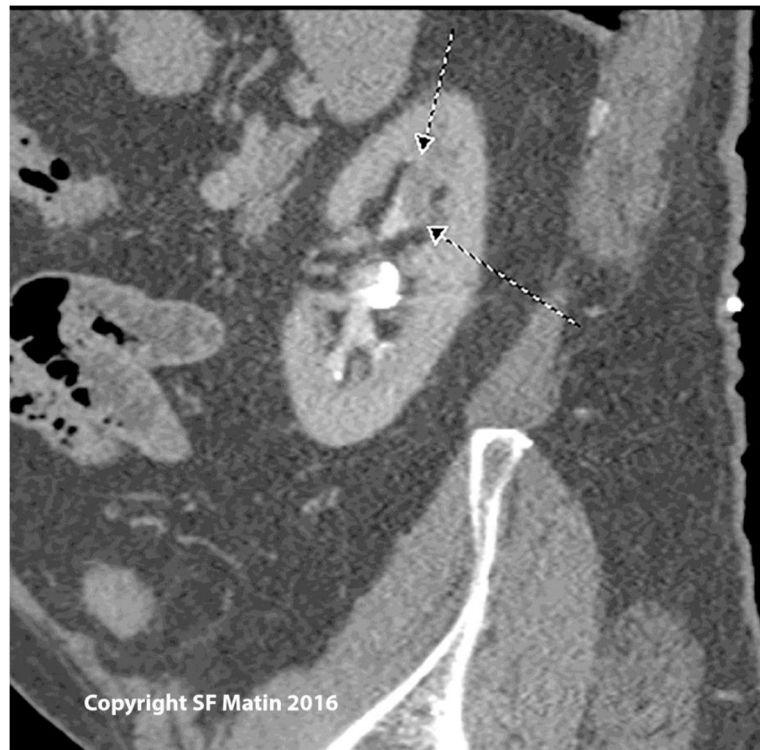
Sagittal view of a computed tomography scan showing a filling defect representing a soft tissue mass in the upper pole of the left collecting system, in a patient with prior endoscopic therapy for low grade left ureteral tumors. Biopsy in this case showed high grade papillary tumor. Nephroureterectomy showed parenchymal invasion (stage pT3).
